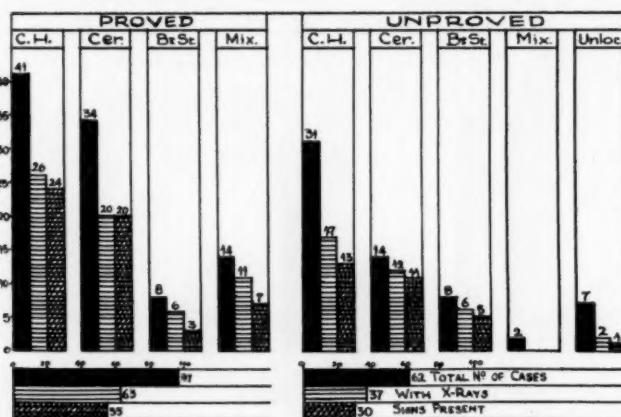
Incidence of signs of intracranial hypertension in simple roentgenograms.
